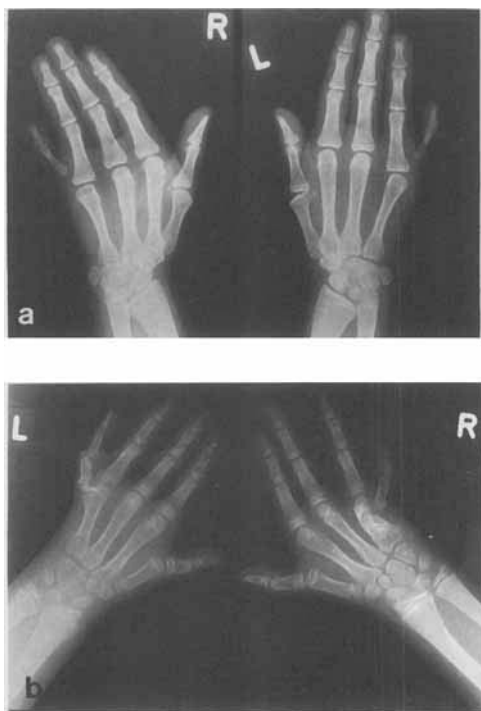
Roentgenograms of the hands of the girl (a) and the boy (b).
